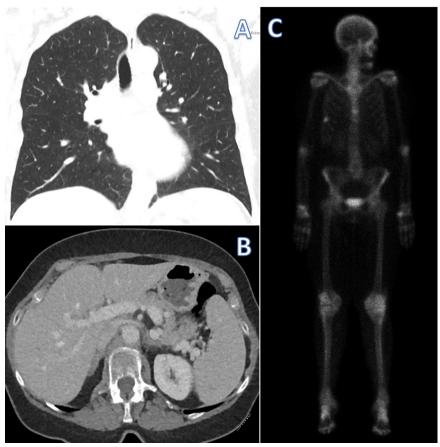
(A) CT scan coronal view of the chest showing no pulmonary metastasis. (B) CT scan axial view of the abdomen with intravenous contrast administration showing no abdominal metastasis. (C) Bone scan showing no bone metastasis, with focal hyperactivity noted in the known right breast lesion. CT, computed tomography.
